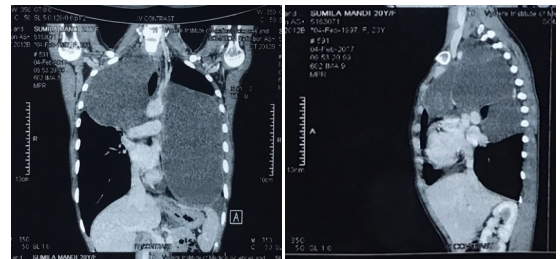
CT thorax showing bilateral cystic lesions with involvement of anterior, superior and superior mediastinum.
